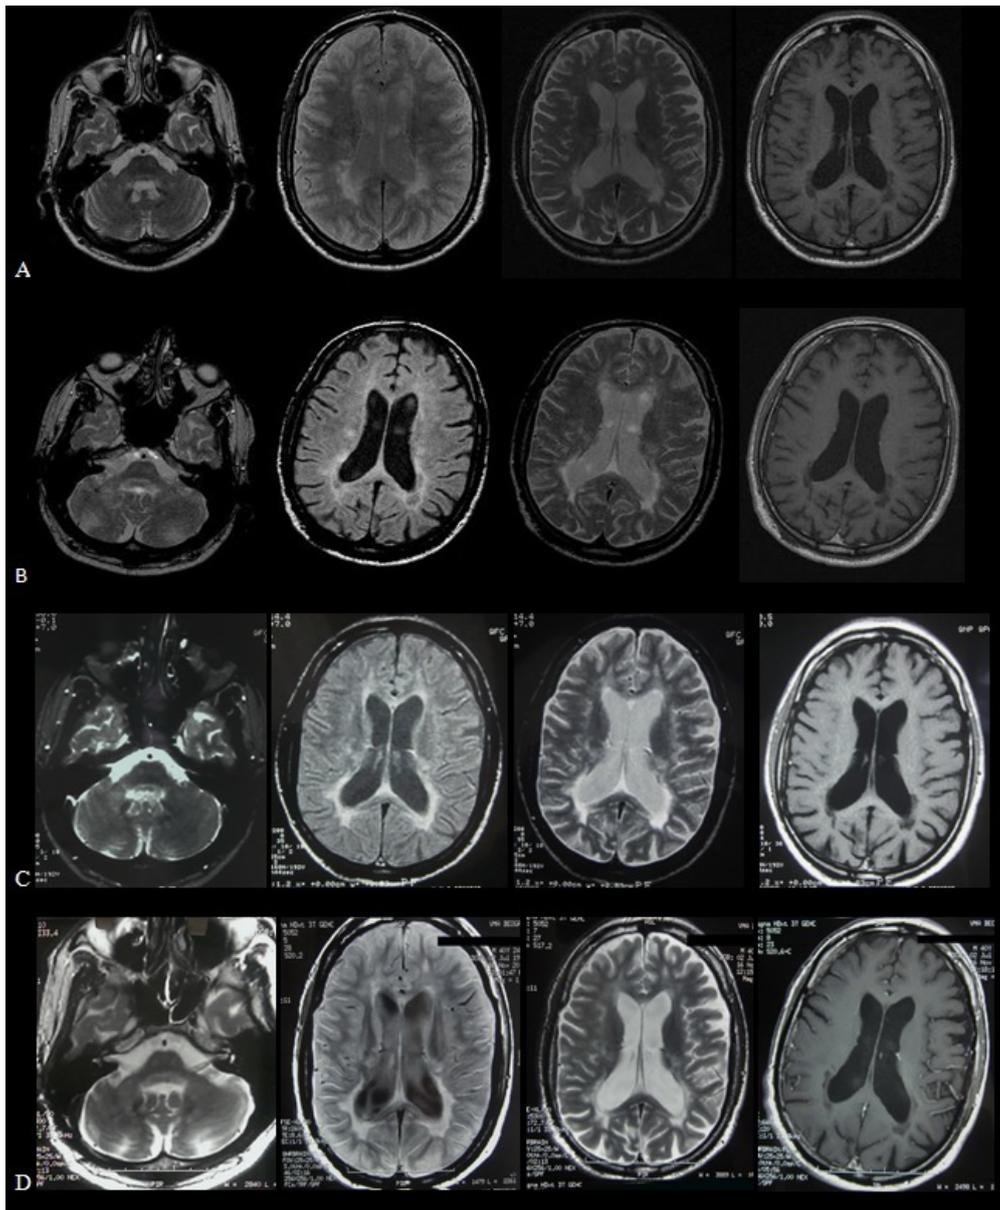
a) Baseline magnetic resonance imaging (MRI) findings: axial T2 (TR 3241, TE 100), axial PD (TR 3241, TE 33), axial T2 (TR 3241, TE 100), axial T1 post-contrast (TR 610, TE 12). High-grade brain atrophy, infratentorial and periventricular white matter demyelinating lesions, no post-contrast enhancement are shown; b) MRI at the 2-year follow-up: axial T2 (TR 2100, TE 100), axial PD (TR 2100, TE 20), axial T2 (TR 2100, TE 100), axial T1 post-contrast (TR 613, TE 12). Mild progression of brain atrophy, a few new demyelinating lesions, no post-contrast enhancement; c) MRI at the 3-years follow-up: axial T2 (TR 2200, TE 95), axial PD (TR 2200, TE 35), axial T2 (TR 2200, TE 95), axial T1 post contrast (TR 500, TE 14). Slight progression of brain atrophy, no new demyelinating lesions, no contrast enhancement; d) MRI at the 10-year follow-up: axial T2 (TR 5300, TE 72), axial PD (TR 2600, TE 86), axial T2 (TR 5300, TE 72), axial T1 post-contrast (TR 660, TE 20). Mild brain atrophy progression mainly infratentorial, no new demyelinating lesions, no post-contrast enhancement.
